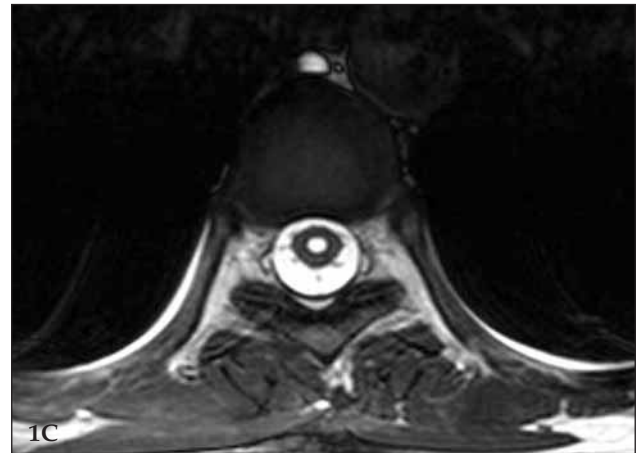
MRI of the older sister A,B. Sagittal and C. axial T2-weighted images show syringomyelia between the T6-T8 levels. The cranio-cervical junction is normal. Tonsillar ectopia is not present.
